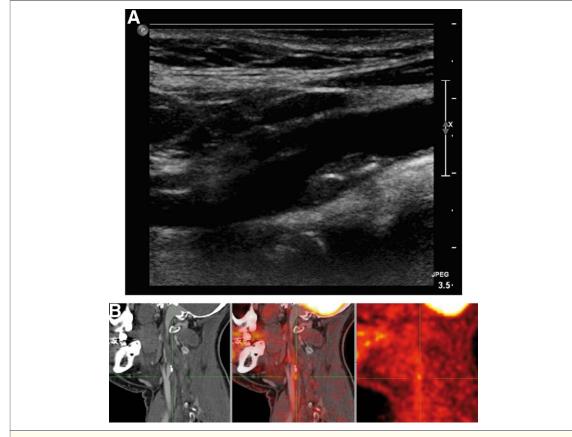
Ultrasound and PET in Carotid Artery Disease
